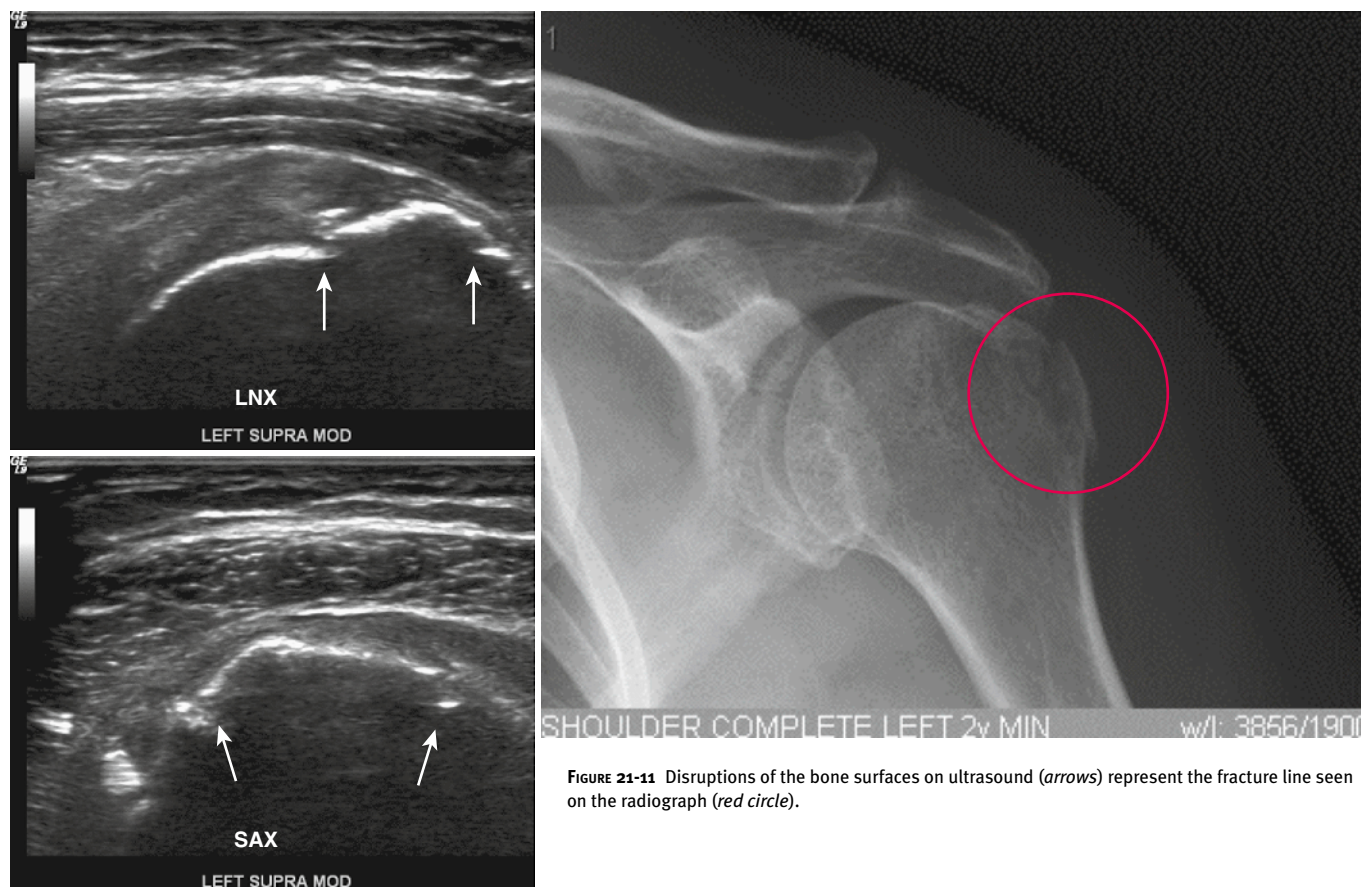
Disruptions of the bone surfaces on ultrasound (arrows) represent the fracture line seen on the radiograph (red circle).
